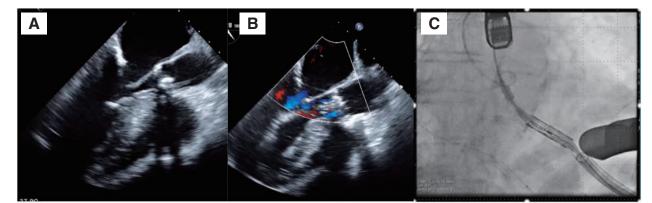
Transesophageal echocardiography showing the incorrect wire route around the LVOT and aortic valve (A). The THV became lodged below the aortic valve, and the delivery system bent (B) during the first THV placement attempt. Fluoroscopy also shows the THV lodged below the aortic valve and the bent delivery system (C). LVOT: left ventricular outflow tract; THV: transcatheter heart valve
